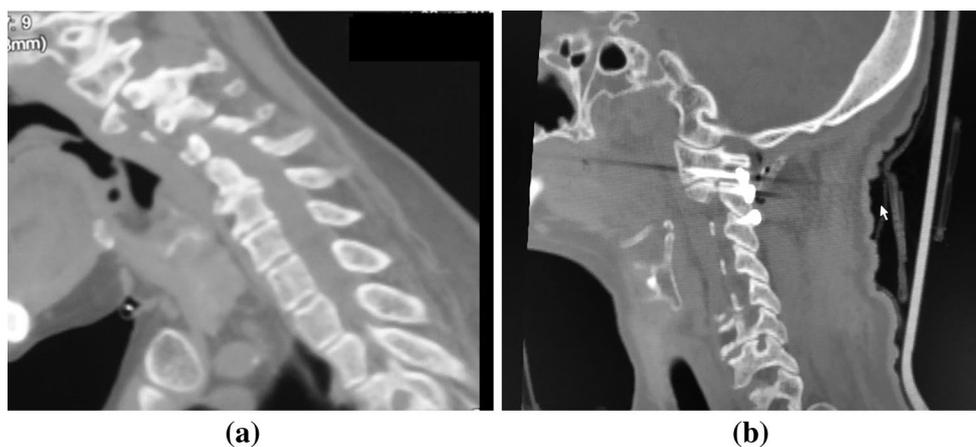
a CT scan showing fracture of the C2 pedicle. b CT scan showing C1–2 fixation using plate and screws. Transarticular C2–3 screw insertion is seen
